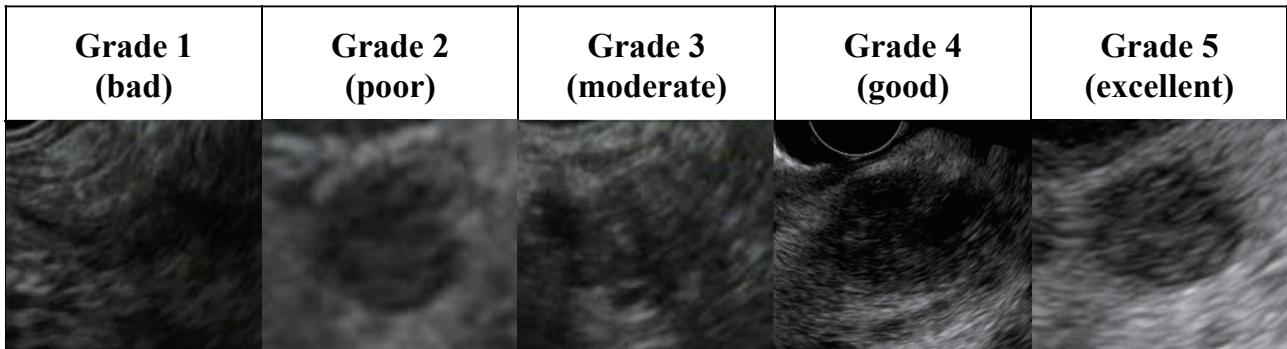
Representative EUS imaging ~Internal echo~. Representative images from each EUS system depicting the internal echo of lesions. As the grade increases, the internal structure of the lesion becomes clearer. EUS, endoscopic ultrasonography.
